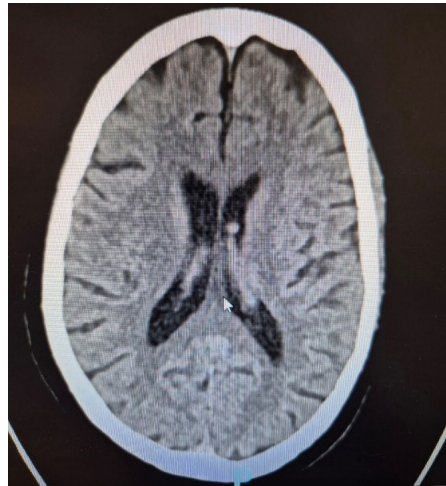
Non-contrast CT scan of the brain demonstrating no acute intracranial hemorrhage, mass lesion, or territorial infarction.
